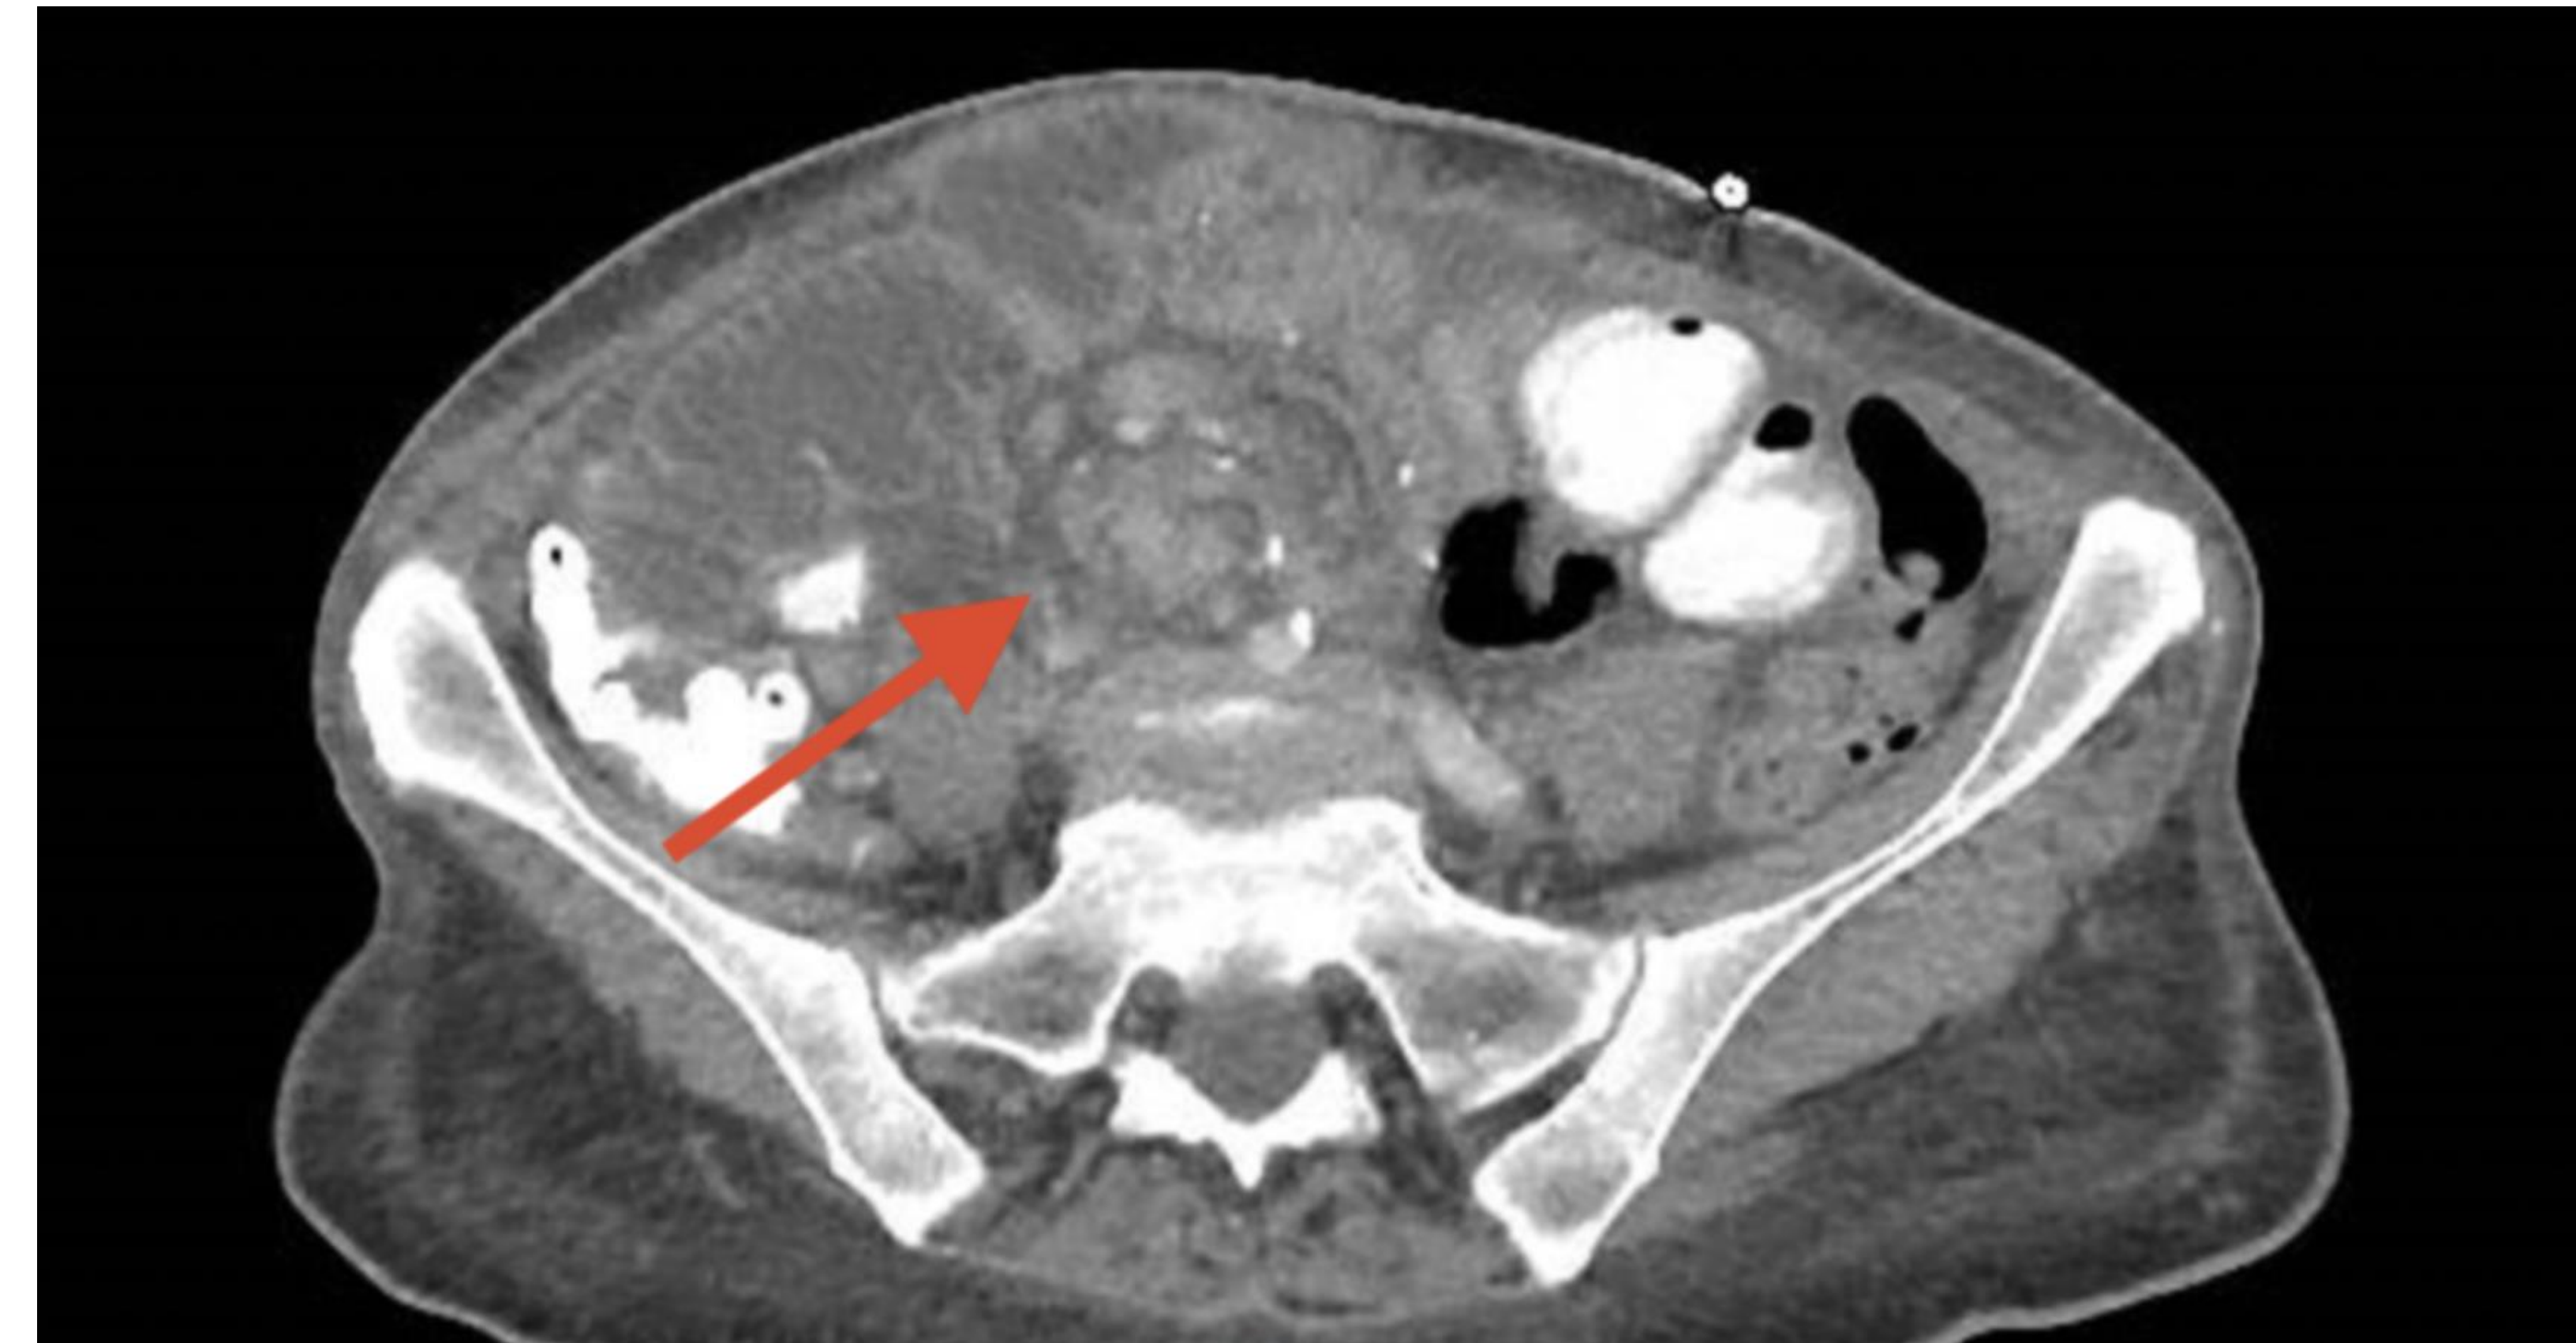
CT A/P: small bowel obstruction with dilation of both the roux limb and pancreaticobiliary limb and swirling of the small bowel mesentery.
